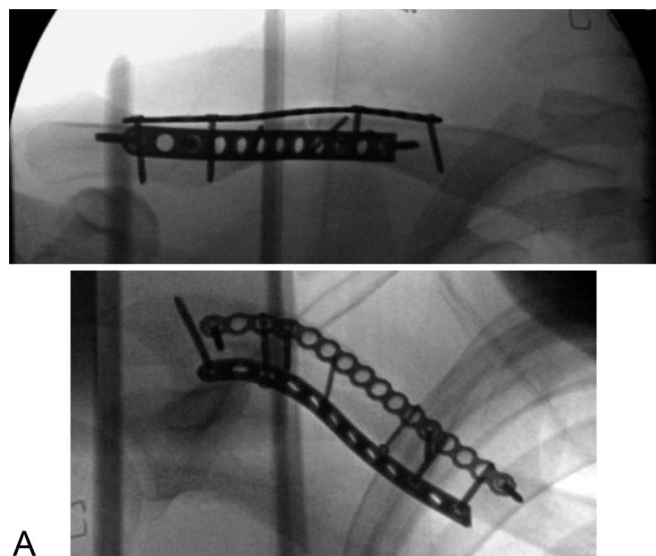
A, Orthogonal intraoperative imaging of a patient with a diaphyseal clavicle fracture treated with 2.0-mm lag screws and dual superior 2.4-mm/anterior 2.7-mm mini-fragment plates in neutralization mode. B, Radiograph demonstrating a healed diaphyseal clavicle fracture fixed with DmF plating in the same patient.
